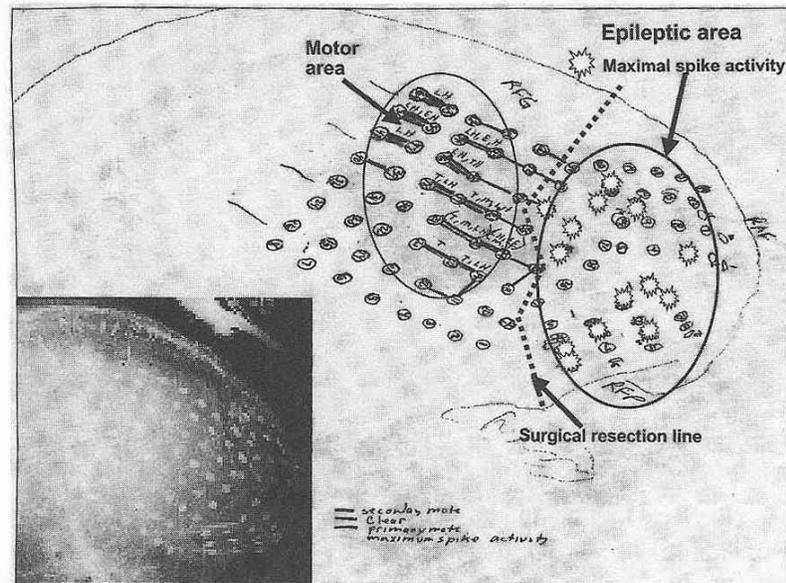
The inset is a skull x-ray showing the grid in place. The electrodes are visible. Our map of the cortex shows the areas of seizure discharges and the areas of motor activity located by stimulation. The dotted line is the guide for the surgeon to follow in removing the frontal cortex (the epileptic area) and avoiding the motor areas.
